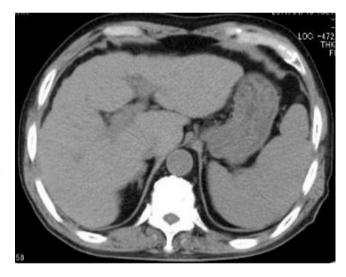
CT scan in liver cirrhosis. CT shows the liver with irregular surface, enlargement of left lobe, and splenomegaly
